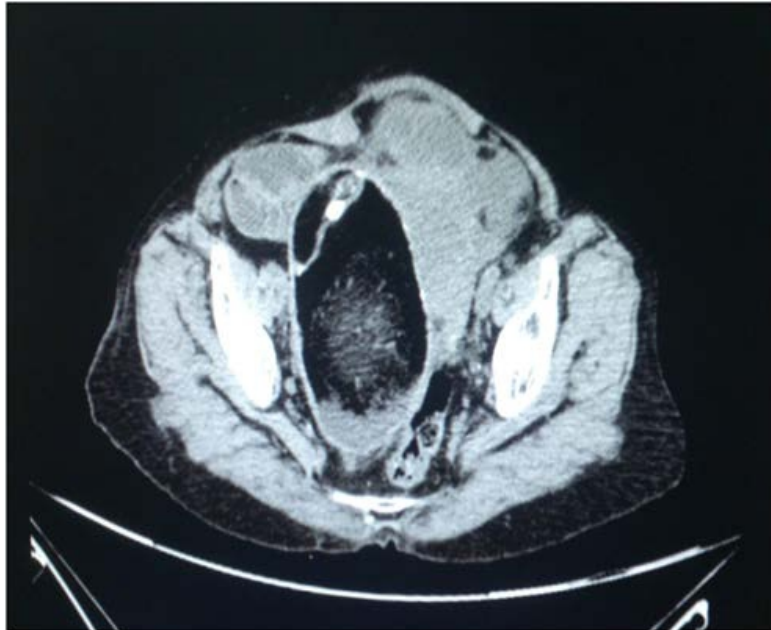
CT (transverse section) of pelvis.
